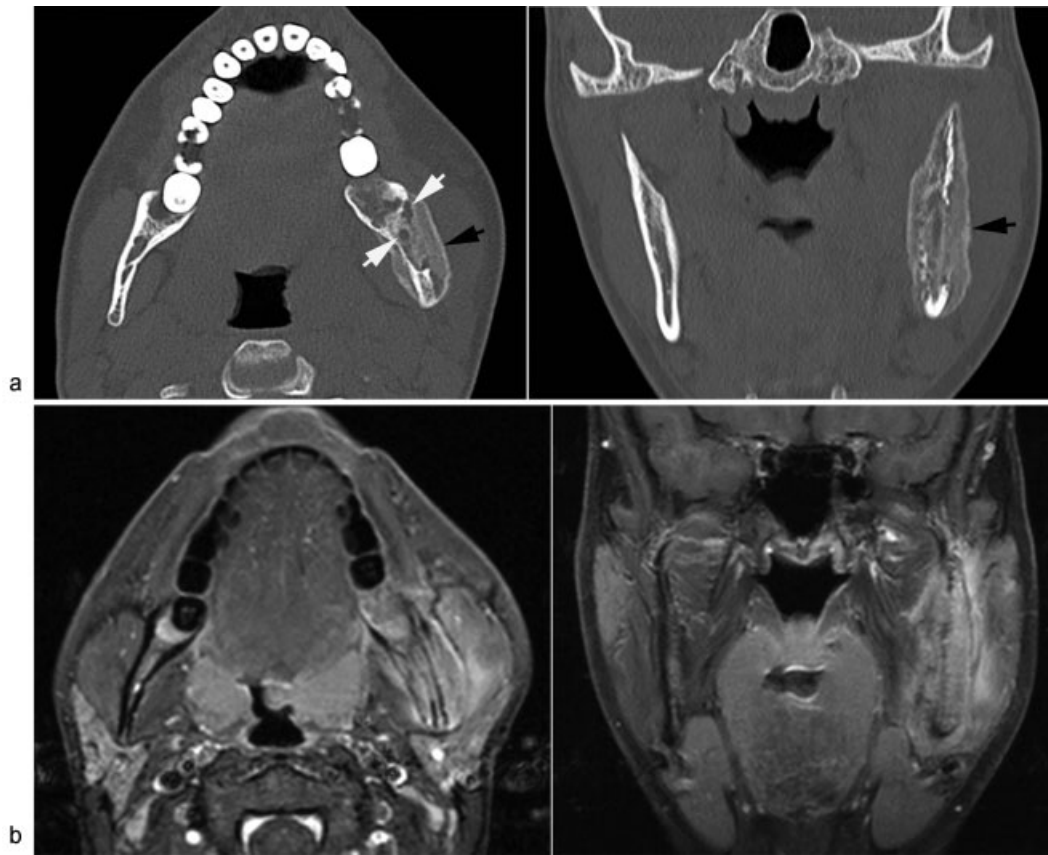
Mandibular bone involvement. (a) Computed tomography of an 18-year-old man, axial slice and coronal reconstruction, showing lytic intramedullary destructions (white arrows) and organized periosteal new bone formation (black arrows). (b) MRI, postcontrast T1-weighted fat-saturated, axial and coronal image, shows enhancing bone and periosteal new bone formation in addition to a voluminous and slightly enhancing masseter muscle on the left side.
